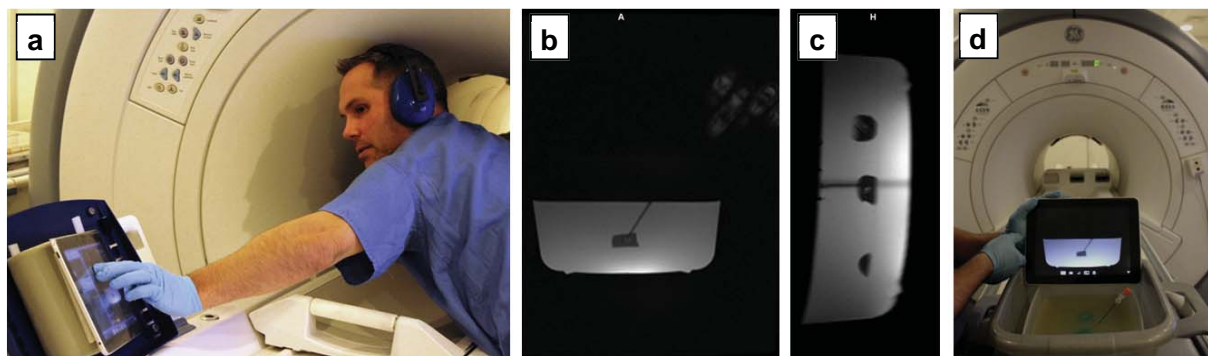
MR guided needle biopsy: a) Adjustments of imaging slice b) Sagittal real-time MR images with needle c) Double oblique orientation d) Successful needle puncture: Touch screen vs. visual inspection
